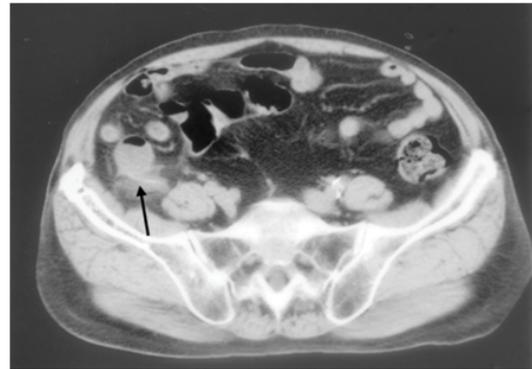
Abdominal computed tomography (CT) revealed an elongated radiopaque material (arrow) in the appendix which was surrounded by dense fibrous tissue.
